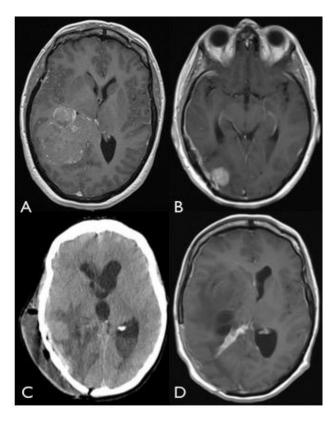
a, T1+contrast MRI taken at index presentation showing the tumour within the trigone of the right lateral ventricle. b, T1+contrast MRI taken at time of first recurrence, 8 months later. Note that the recurrence was distant to the site of the original tumour. c, CT+contrast taken at time of presentation with sepsis syndrome. There was dilatation of the ventricles and fluid levels in both lateral ventricles. d, T1+contrast MRI taken three months after her third operation. There is no ventriculomegaly and some enhancing gliotic tissue at the site of previous surgrery.
